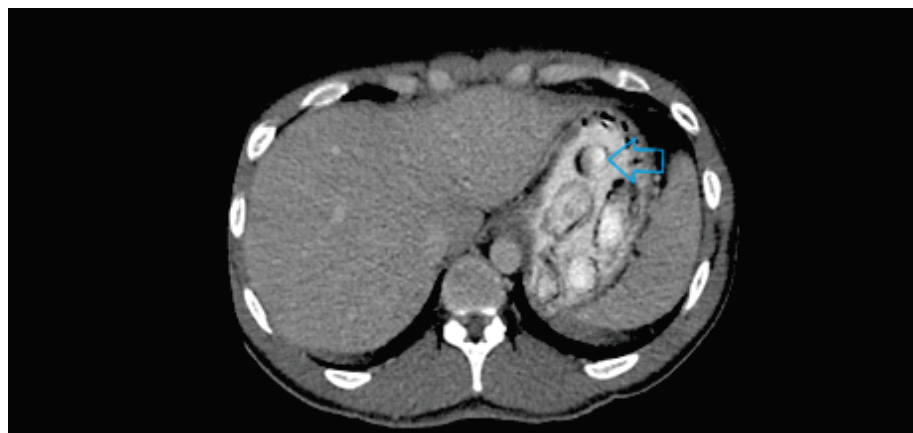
Contrast CT in axial plane shows numerous foreign bodies in stomach (arrow head)
